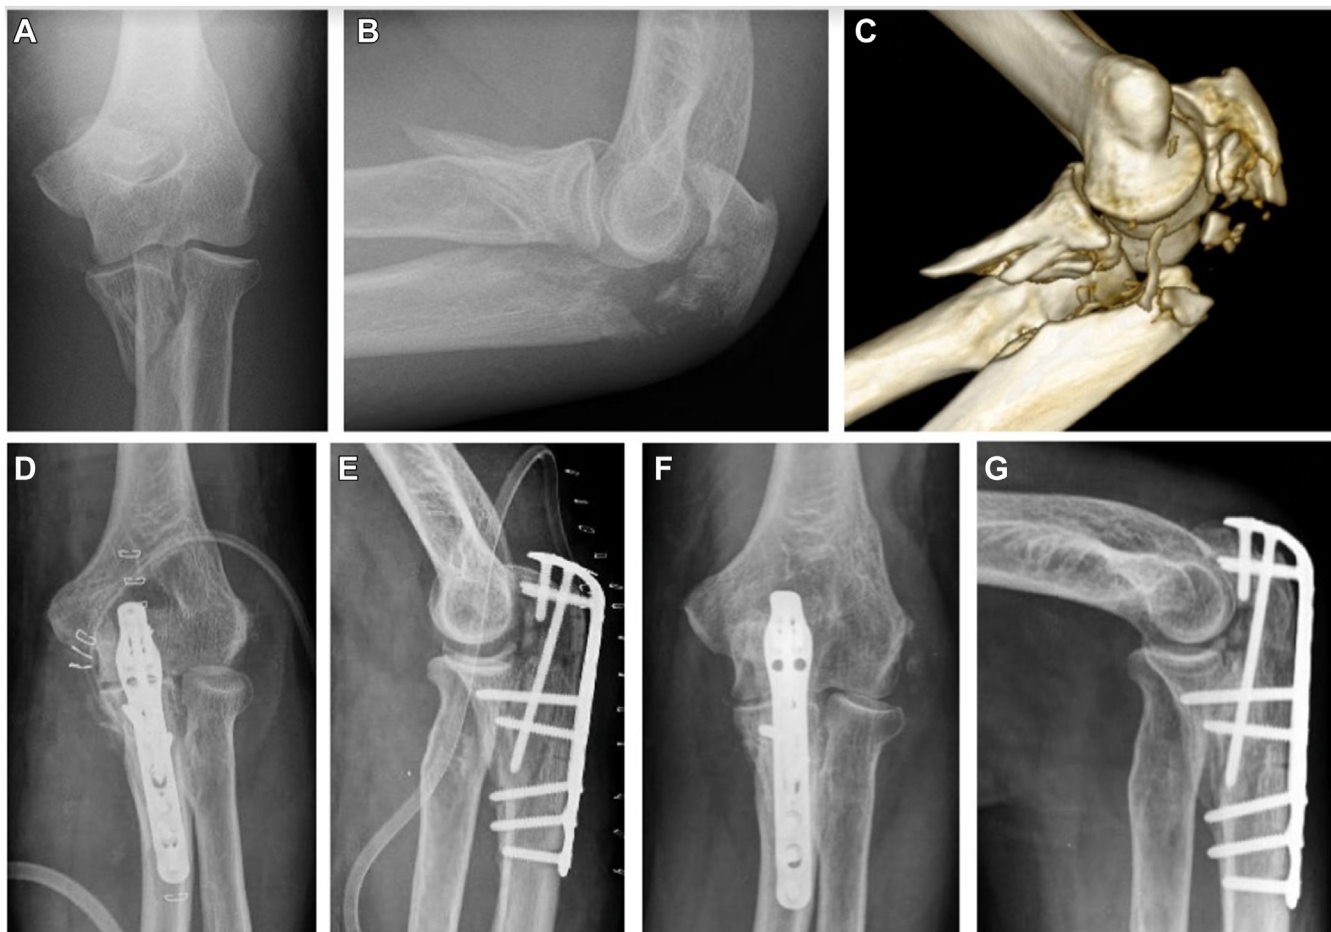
Case 21 example of TOFD with a basal subtype 2 coronoid fracture. (A–C) preoperative right elbow fracture-dislocations (A) AP view X-ray, (B) lateral view X-ray, (C) CT scan 3D reconstruction. (D and E) postoperative X-ray, (D) AP view and (E) lateral view. (F and G) postoperative 3rd month X-ray; (F) AP view and (G) lateral view. CT, computed tomography; TOFD, transolecranon fracture-dislocation.
